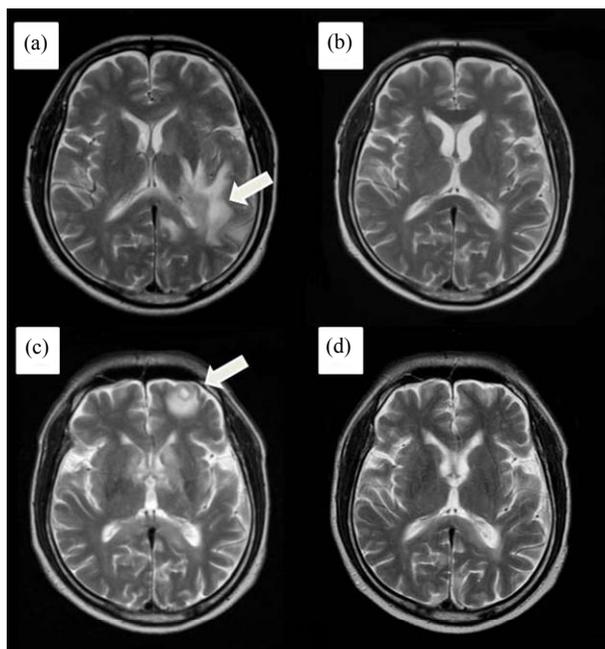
(a) High-intensity mass in the left temporal lobe to parietal lobe on T2 weighted MRI (Arrow); (b) T2 weighted MRI after four cycles of MIND-E therapy; (c) Second CNS recurrence in the left frontal lobe on T2 weighted MRI (Arrow); (d) T2 weighted MRI after three cycles of R-MIND-E therapy.
